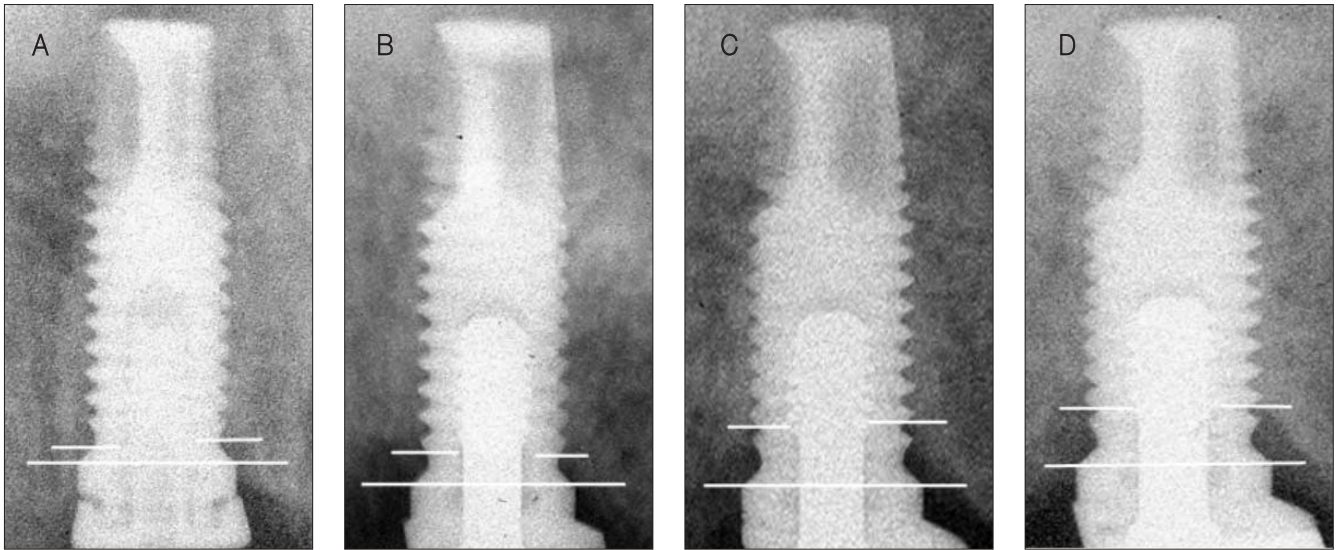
Mesial and distal measuring of bone resorption on intraoral standard radiographs. (a) immediately after implant installation (b) 8 months healing period after implant installation (c) 1 year after loading on the implant (d) 2 years after loading on the implant.
